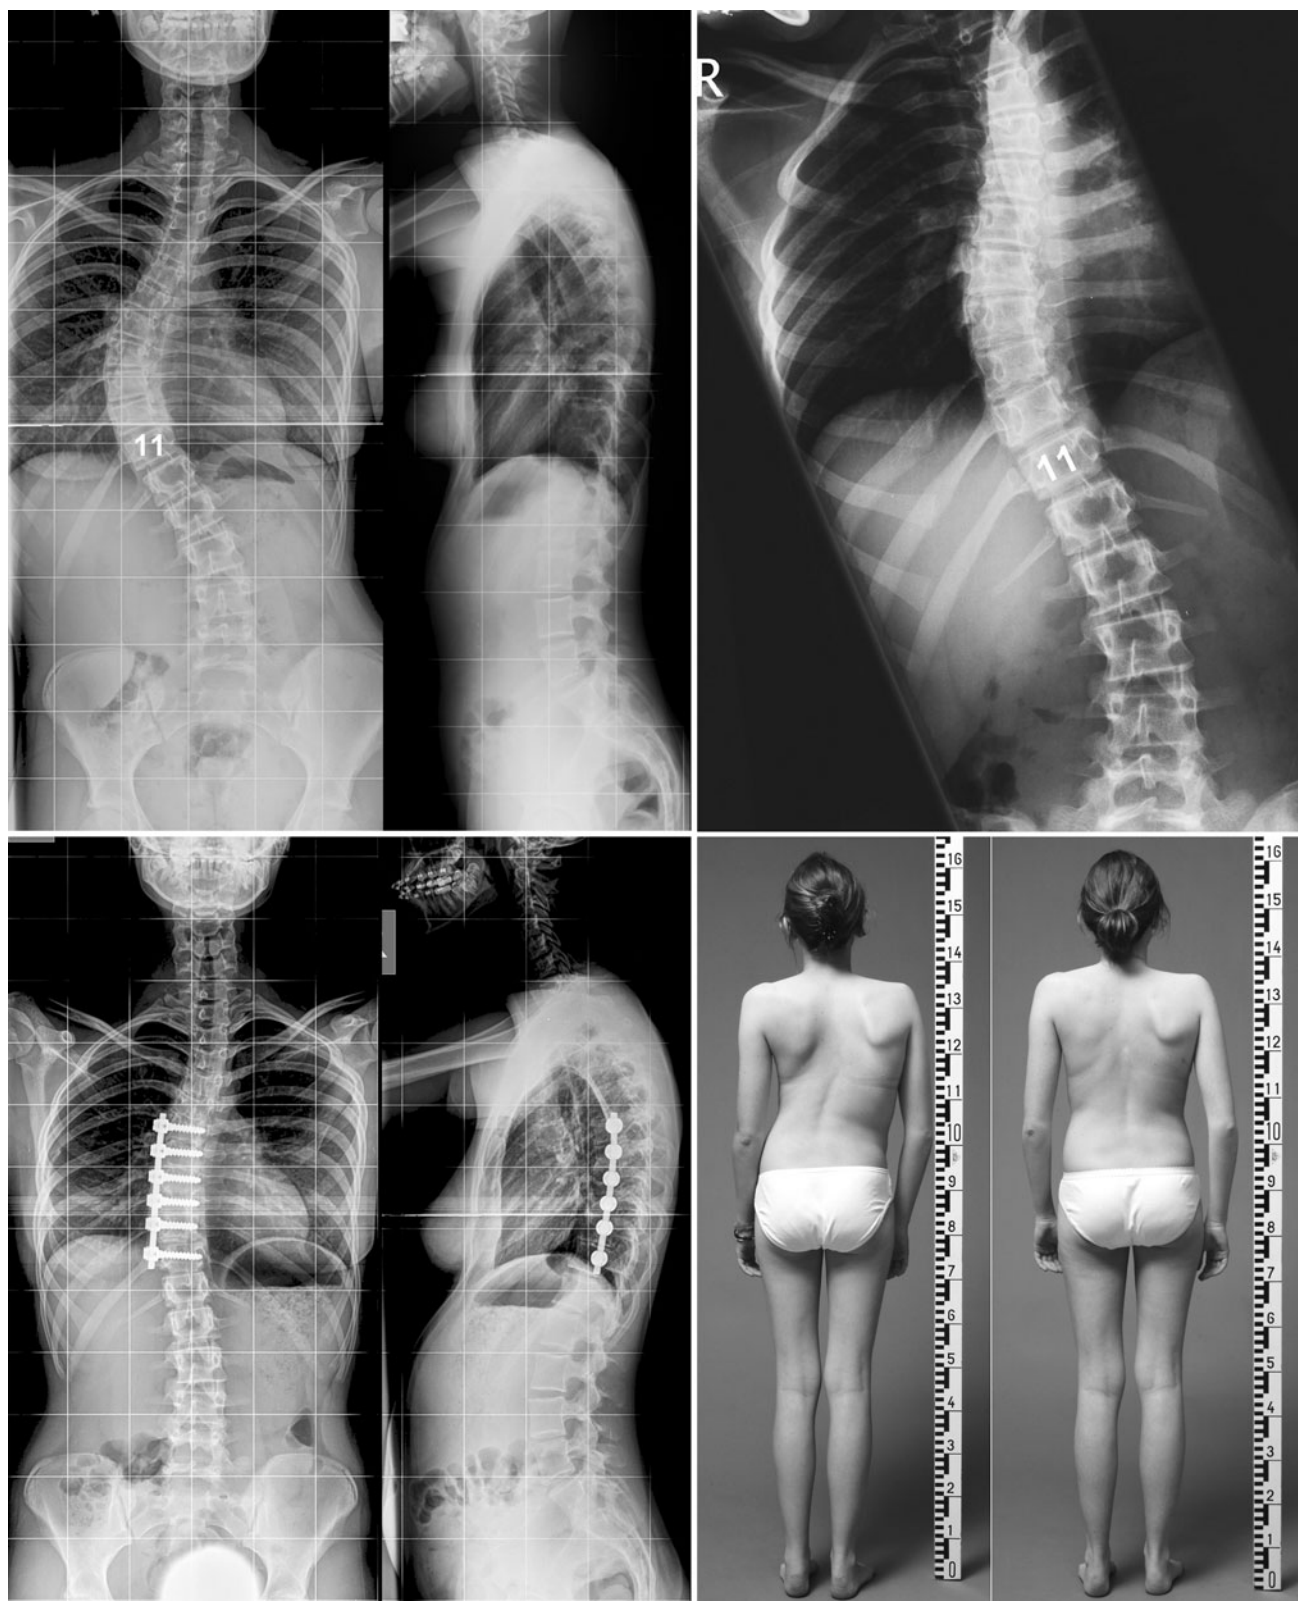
A single thoracic curve. Disc T11/T12 opens in supine bending. T11 is distal LIV. In anteroposterior standing radiograph the apex is disc T8/T9. There are three vertebrae (T9, T10, T11) distal to
